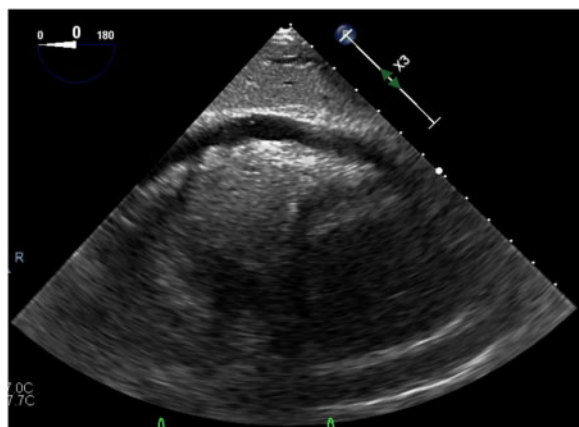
Echocardiographic view of pericardial effusion.
